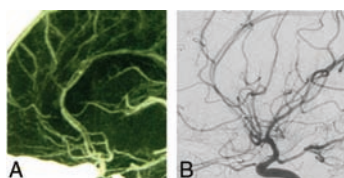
Three-dimensional CTA (A) and left carotid angiogram (B) demonstrating disappearance of the aneurysm and patency of the left pericallosal artery.
